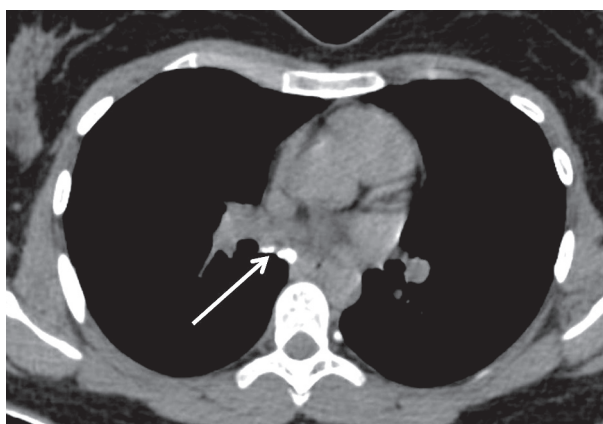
Plain axial computed tomography mediastinal window image showing calcified sub-carinal nodes (white arrow)
